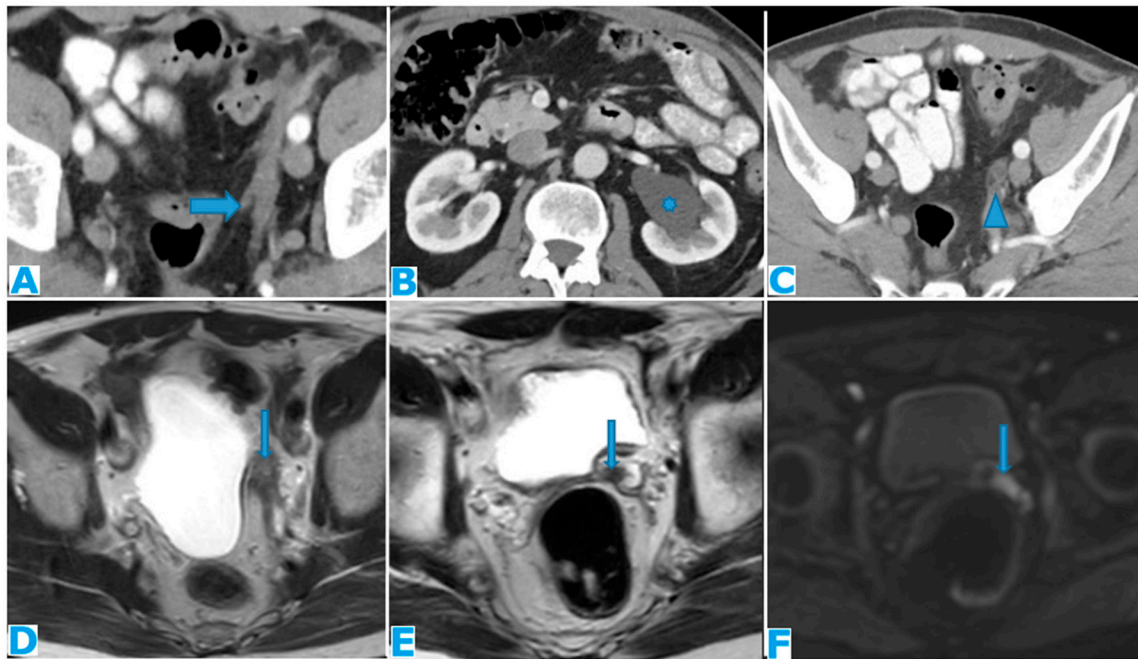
Axial CE-CT (A, B, C). Axial T2WI (D and E), DWI (F). PC from mucinous adenocarcinoma of the appendix: Notice the peritoneal deposit within the left lateral pelvis (arrow on A) as an elongated soft tissue mass. The patient presented with a left uretero-hydronephrosis (* on B) due to the pelvic deposit which obstructed the ureter (arrowhead on C). Paravesical spaces are peritoneal recesses that cover on each side the distal ureter, the seminal vesicle, and the deferent duct. Note the deposit within the left paravesical space and how it obstructs the left ureter (arrow on C). The deposit also follows the course of the left deferent duct (arrow on E and F).
